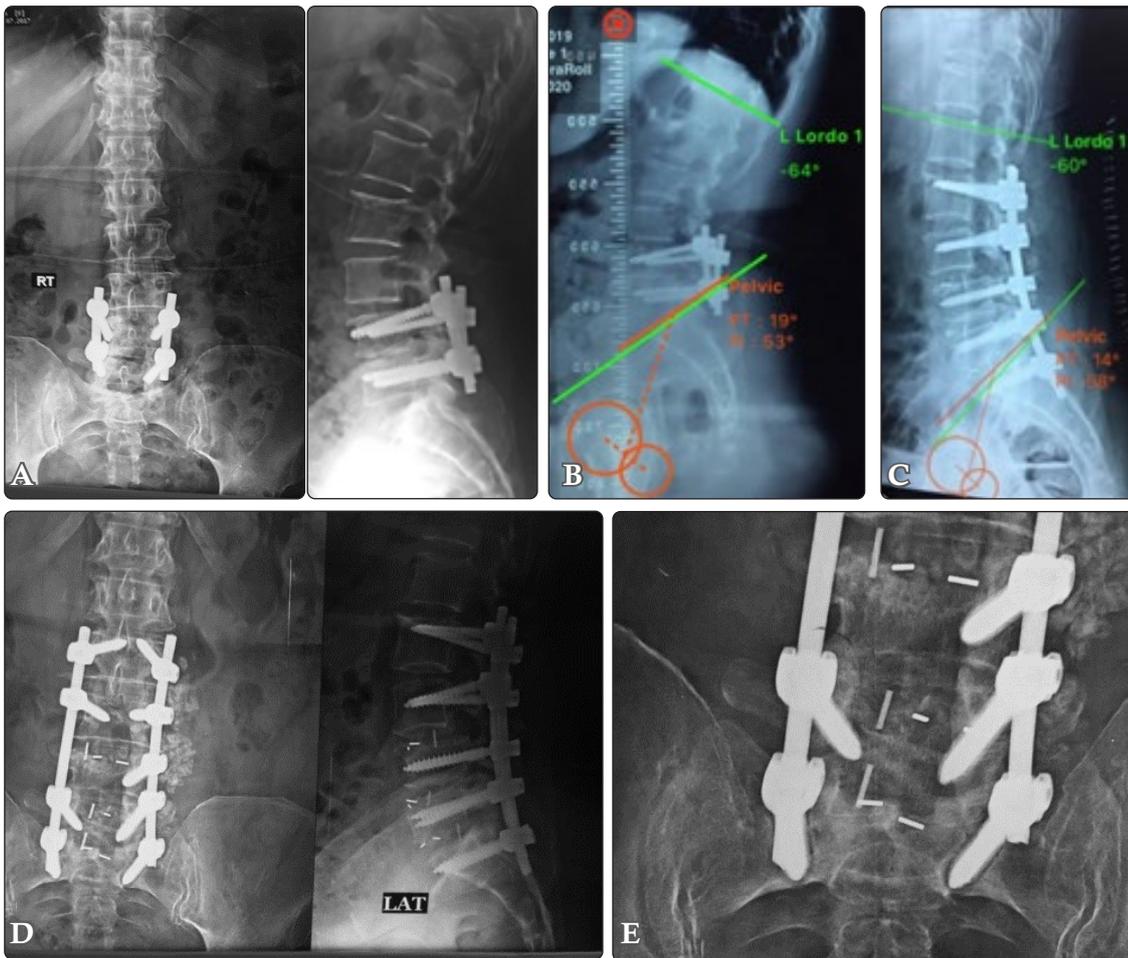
(A) Preoperative AP and lateral X-ray. (B) Preoperative lateral X-ray with measurement of LL: -64; PI: 53; PT: 19. (C) Postoperative lateral X-ray showing measurement LL: -60; PI: 53; PT: 14. (D) and (E) Final follow-up X-ray showing S1 loosening of the screw.
